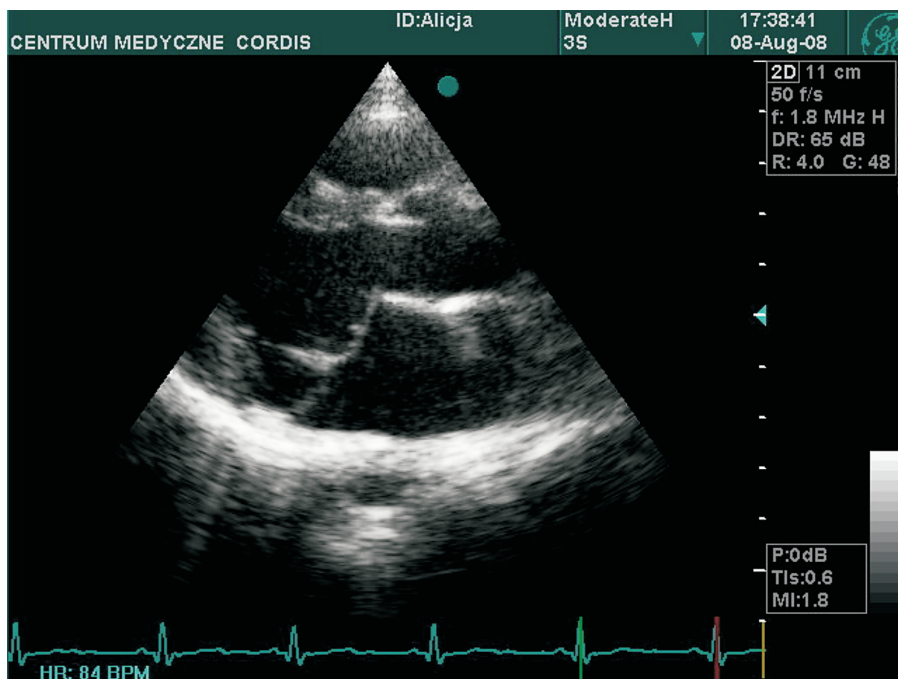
Echocardiography. Mitral valve prolapse (MVP)
